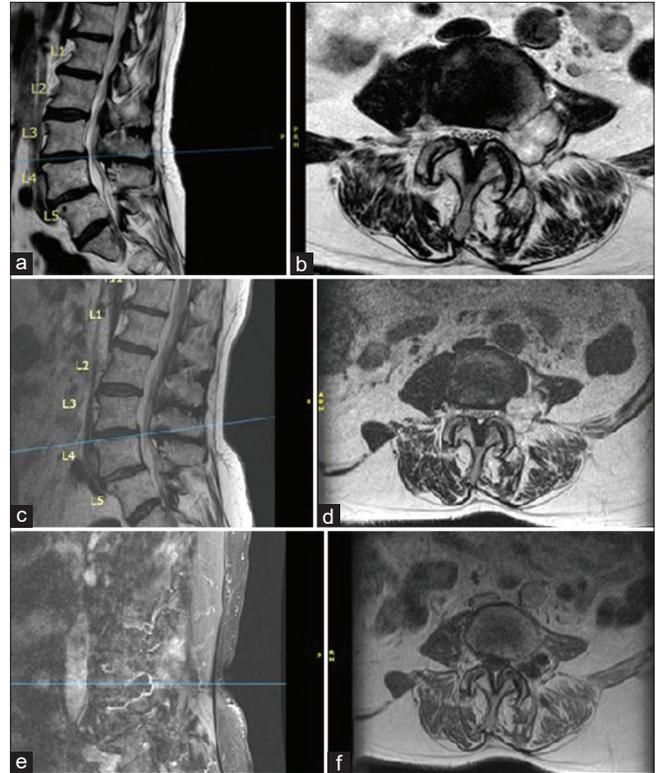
Preoperative magnetic resonance imaging before second surgery. (a) T2 parasagittal without contrast. Progressive enlargement of lesion in the left L3–4 neural foramen with marked mass effect on the exiting L3 nerve visible on (b) T2 axial without contrast at L3–4. (c) T2 parasagittal without contrast. Redemonstration of lobulated T2-hyperintense mass measuring 2.5 × 2.4 × 2 cm centered in the left neural foramen visible on (d) T2 axial without contrast at L3–4. Peripherally enhancing cystic mass visible on (e) T1 parasagittal with contrast and (f) T1 axial with contrast at L3–4.
